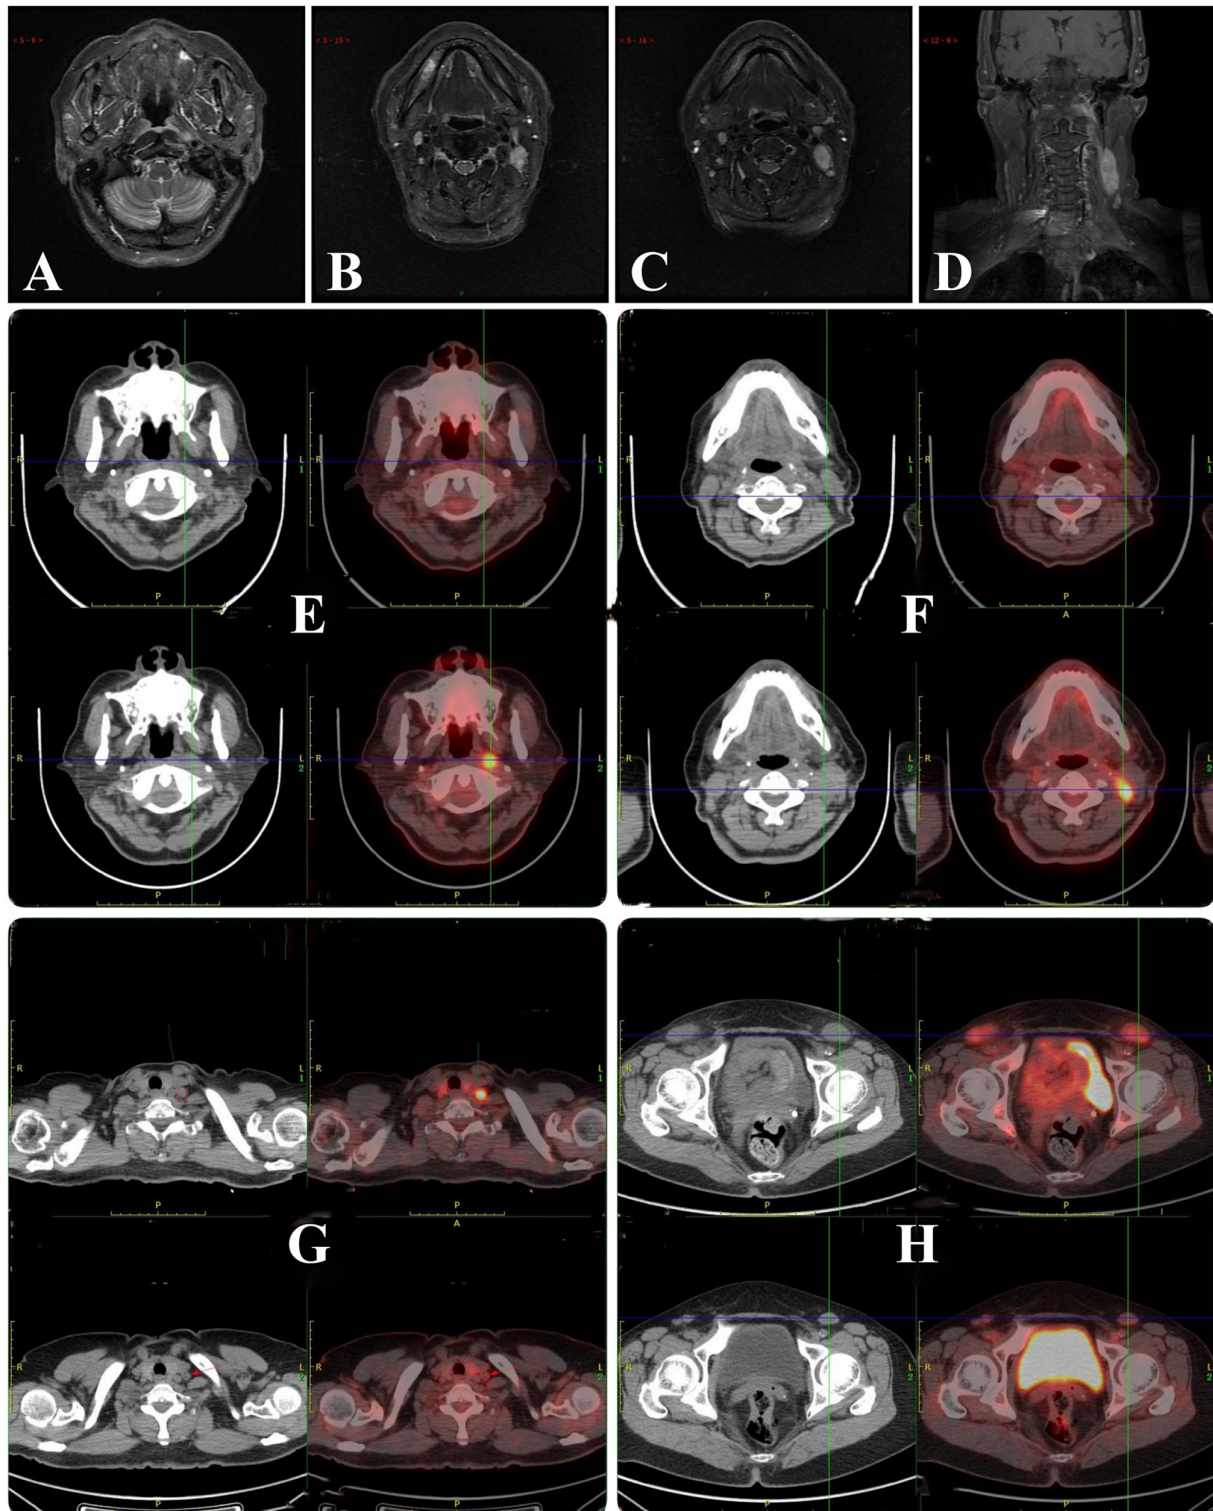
Imaging scans. Initial (A-D) MRI and (E-H) PET/CT scans are presented, with the PET/CT scans compared between pre-treatment (below) and post-treatment (above). (A) Nasopharyngeal mucosa thickening, enlarged lymph nodes in the left cervical lymph node regions: (B and D) RPN, levels II and III were considered possible meta-static tumors. (C and D) Left cervical level II lymph nodes showing extranodal extension (+). In the RPN of the (E) nasopharynx and (F) left neck lymph nodes levels II and III, there was no evidence of metastasis or recurrence. (G) Several left supraclavicular lymph nodes showed interval enlargement on follow-up PET/CT, with the largest measuring ~1.2 cm x1.0 cm and markedly increased glucose metabolism (SUVmax=11.8), in contrast to no abnormal uptake on baseline imaging. (H) Bilateral multiple enlarged inguinal lymph nodes showed interval progression, with the largest measuring ~3.5 cm x2.1 cm and markedly increased glucose metabolism (SUVmax=6.2), compared with a prior SUVmax of 2.5 on baseline imaging. PET, positron emission tomography; SUVmax, maximum standardized uptake volume; RPN, retropharyngeal lymph nodes.
